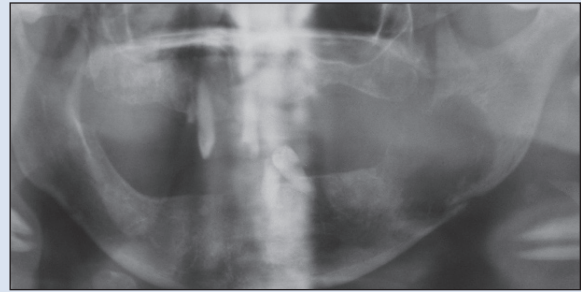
Preoperative orthopantomogram showing large lytic lesion of the left mandibular body and ramus with pathologic fracture through the inferior border. Note overlapping of the edges of the inferior border of the mandible.
